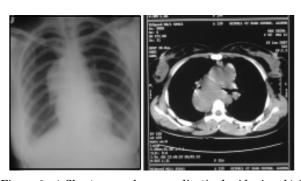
a) Chest x-ray shows mediastinal widening; b) CT scan of the chest :there is a soft tissue density mass in the retro-carinal region
